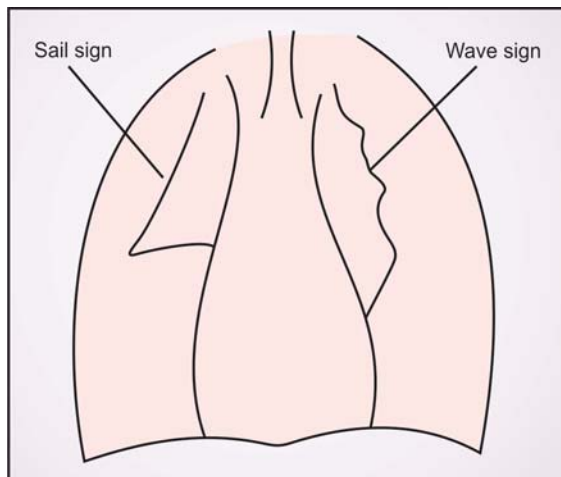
Widened superior mediastinum. Sketch of the X-ray showing shadow produced by the enlarged thymus. Note the “sail” sign on the right and “wave” sign (due to indentation of ribs) on the left. This is an important differential diagnosis in shadow produced by hilar tuberculous adenitis
